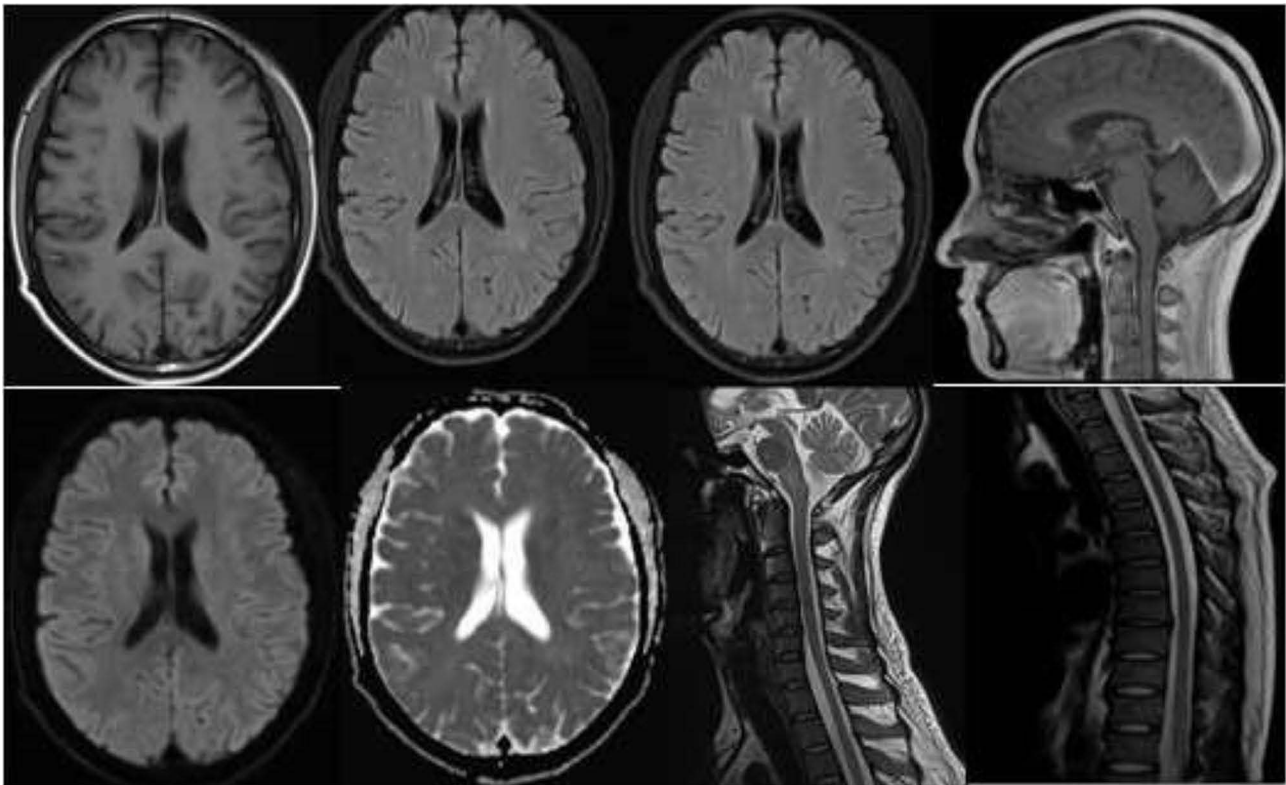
In 2024, MRI reexamination showed that multiple lesions in the brain and spinal cord were basically absorbed.
